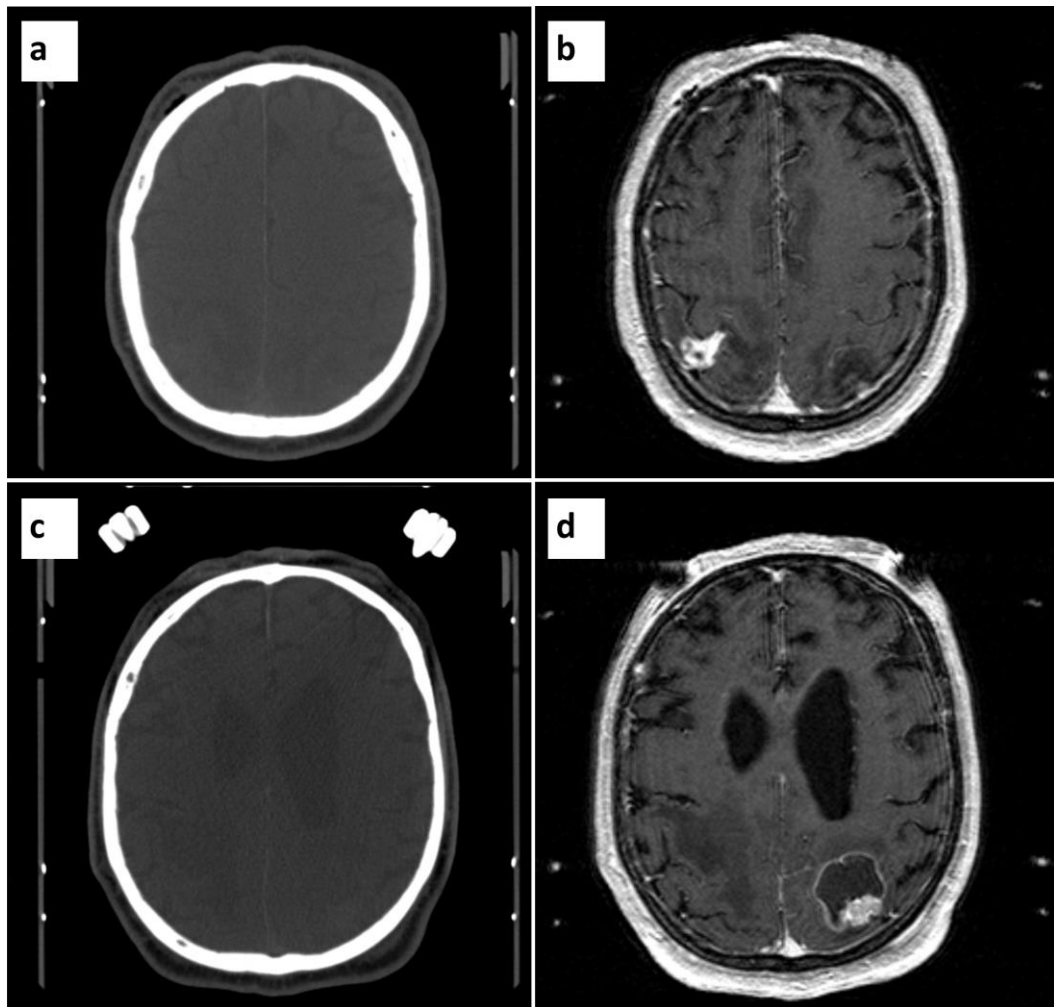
Examples of the superior soft contrast in MR compared to CT for brain tumor delineation. (a, c) Axial slices of a patient with multiple brain metastases. (b, d) Same slices acquired with MRI, following administration of contrast agent.
